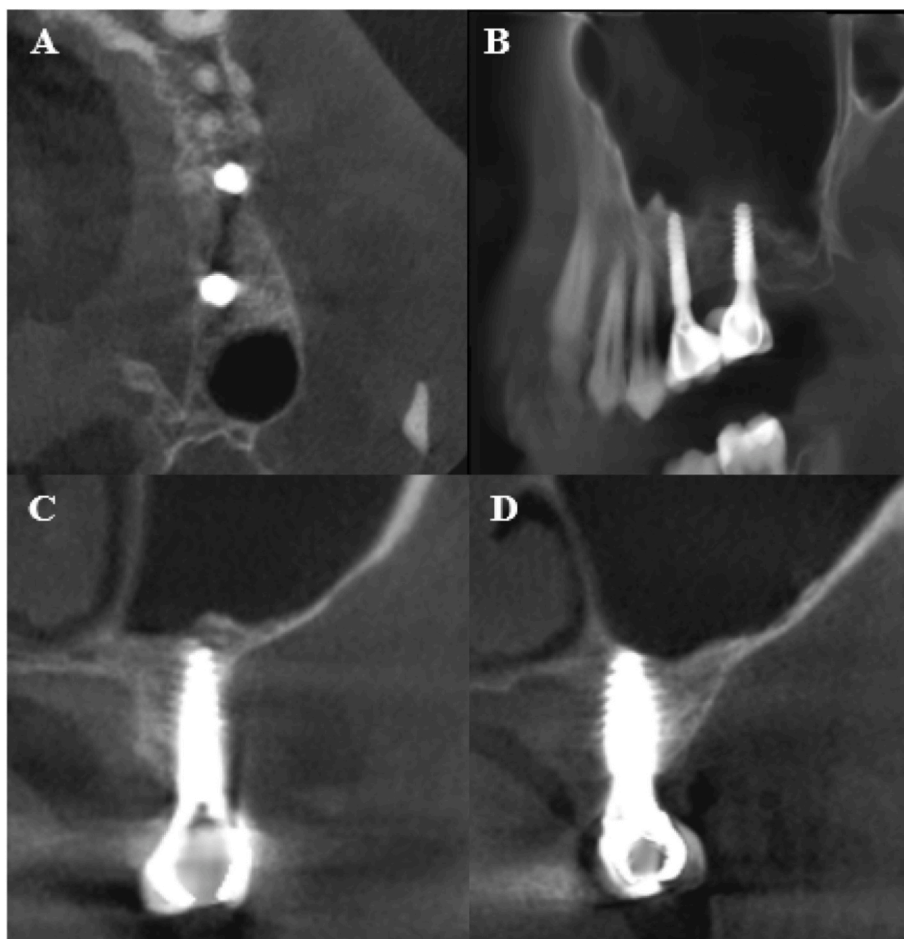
Shows bone height 2.5 years after lifting and implant 2 years after implantation in 26 and 27 regions in CBCT images, C, and D, respectively. The graft material is no longer detectable and the new sinus floor is visible.
